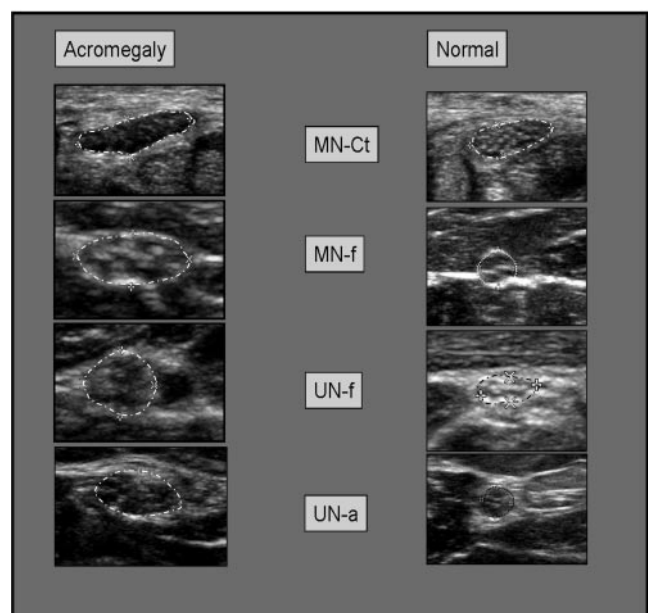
Ultrasonographic comparison of nerves of acromegalic patients (left) and controls (right) at the four points of measurement. The nerve appears enlarged at the four points of sampling. Note the position of the calipers used to calculate the long and short axis of the nerve.
